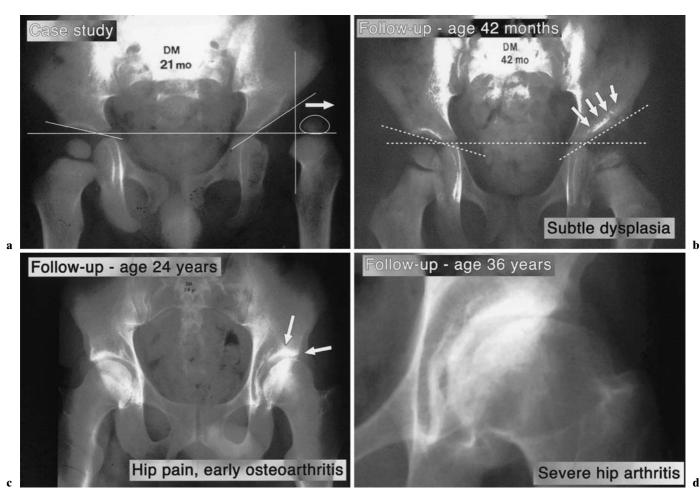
a Radiograph of a 21-month-old girl with complete dislocation of the left hip. The child was treated by a closed reduction followed by spica cast immobilization in a Lorenz-type hip spica cast for 4 months. b Follow-up radiograph at age 42 months. The hip was thought to be adequately reduced. There is no break in Shenton's line. Despite significant residual dysplasia the surgeon thought that the child should
